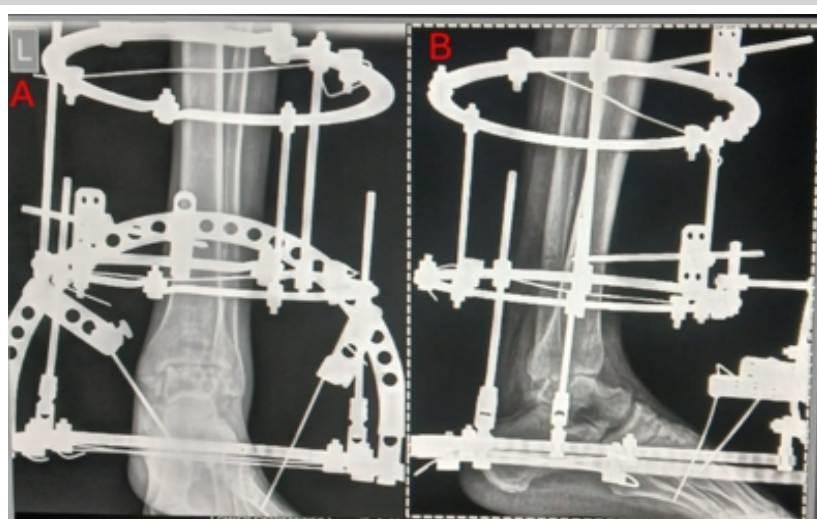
Radiographs of the left ankle at 6 months follow-up demonstrate progressive trabecular bridging across the arthrodesis site, suggestive of ongoing union. The ring fixator remains in situ and has been dynamized to enable controlled axial load sharing. No recurrence of infection or implant-related complication is evident.
